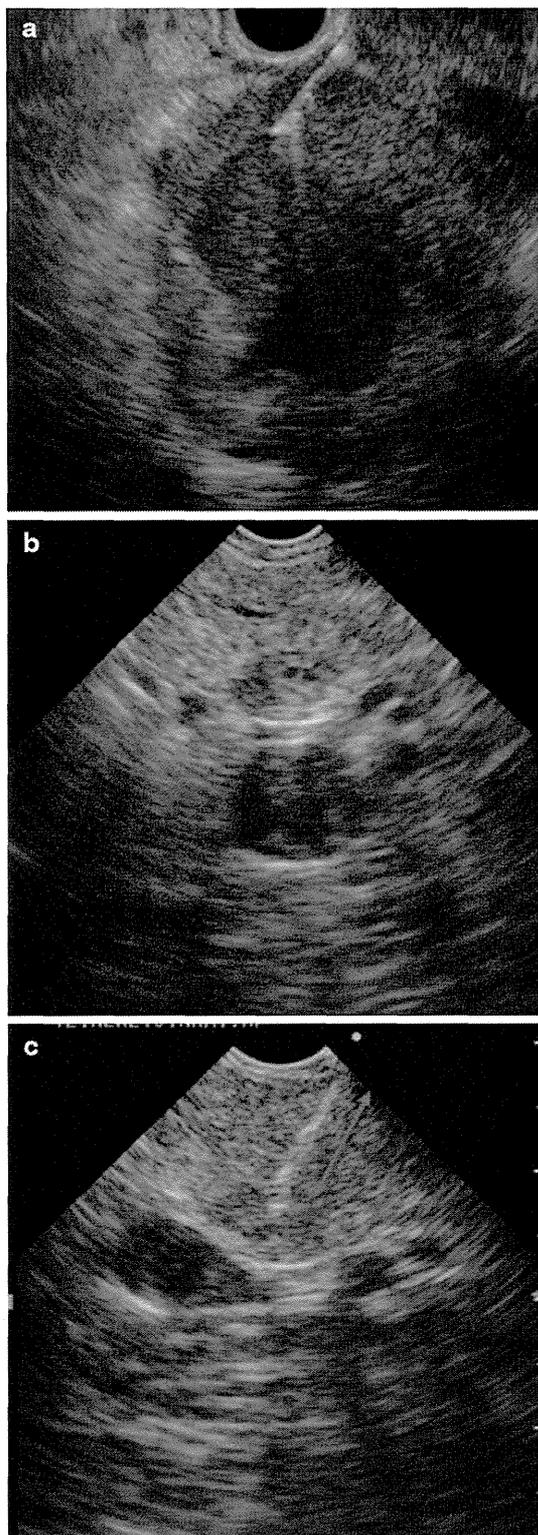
Using ultrasound images, needle pass site was confirmed as via normal pancreatic tissue. a Needle pass was not via normal pancreas. b Needle pass via normal pancreas. c In cases where the needle pass was via normal pancreatic tissue, the length of the needle penetration was measured. The length was measured using a distance marker on the ultrasonography images and assigned to one of 3 categories: <1, 1–2, and >2 cm
